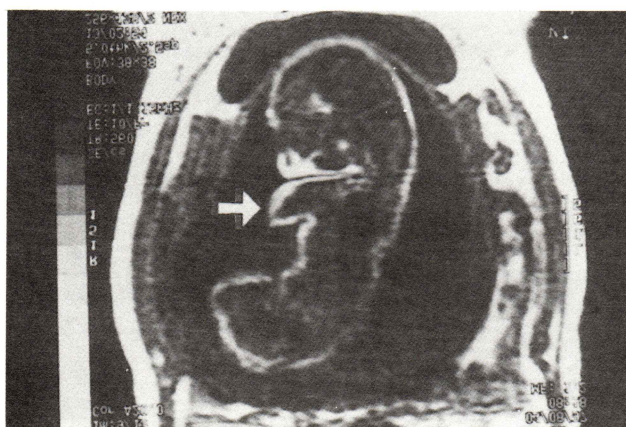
MRI image of phocomelia.
